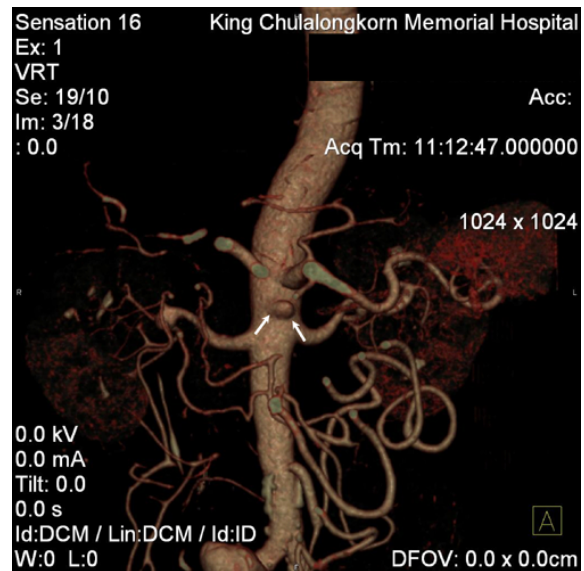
CT angiography reveals an occlusion of the proximal SMA from ligation (arrows) with no demonstrable SMAA. A 3-cm diameter aneurysm of the right common iliac aneurysm is also noted
